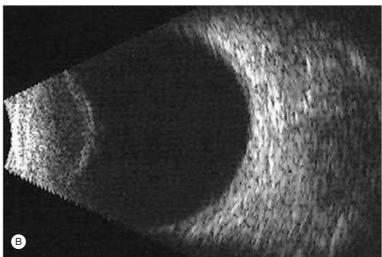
B-Scan Ultrasonographic Images of Advanced Cataract Suggesting the Presence of a Ciliary Body Neoplasm. (A) Anteroposterior slice through cataract. (B) Transverse slice through cataract.
